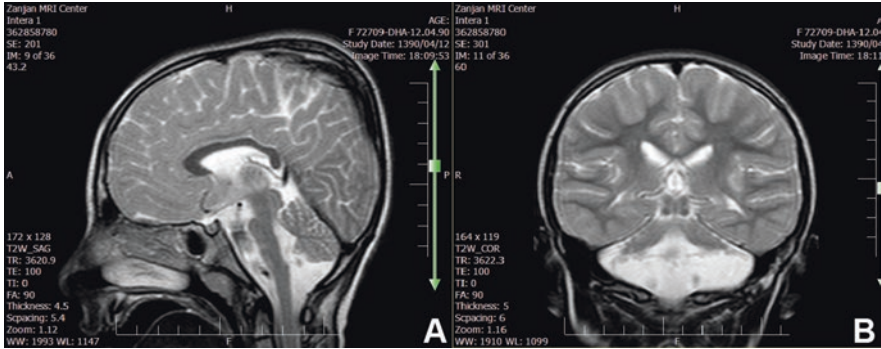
Pontocerebellar hypoplasia. (a) Sagittal T2-weighted brain MR images. The pons is very small but has a relative sparing bulging in its superior part. Vermis hypoplasia predominates at the inferior site. (b) Coronal T2-weighted brain MR images. Cerebellar hemispheric hypoplasia with vermis relatively spared leading to classic dragonfly image
